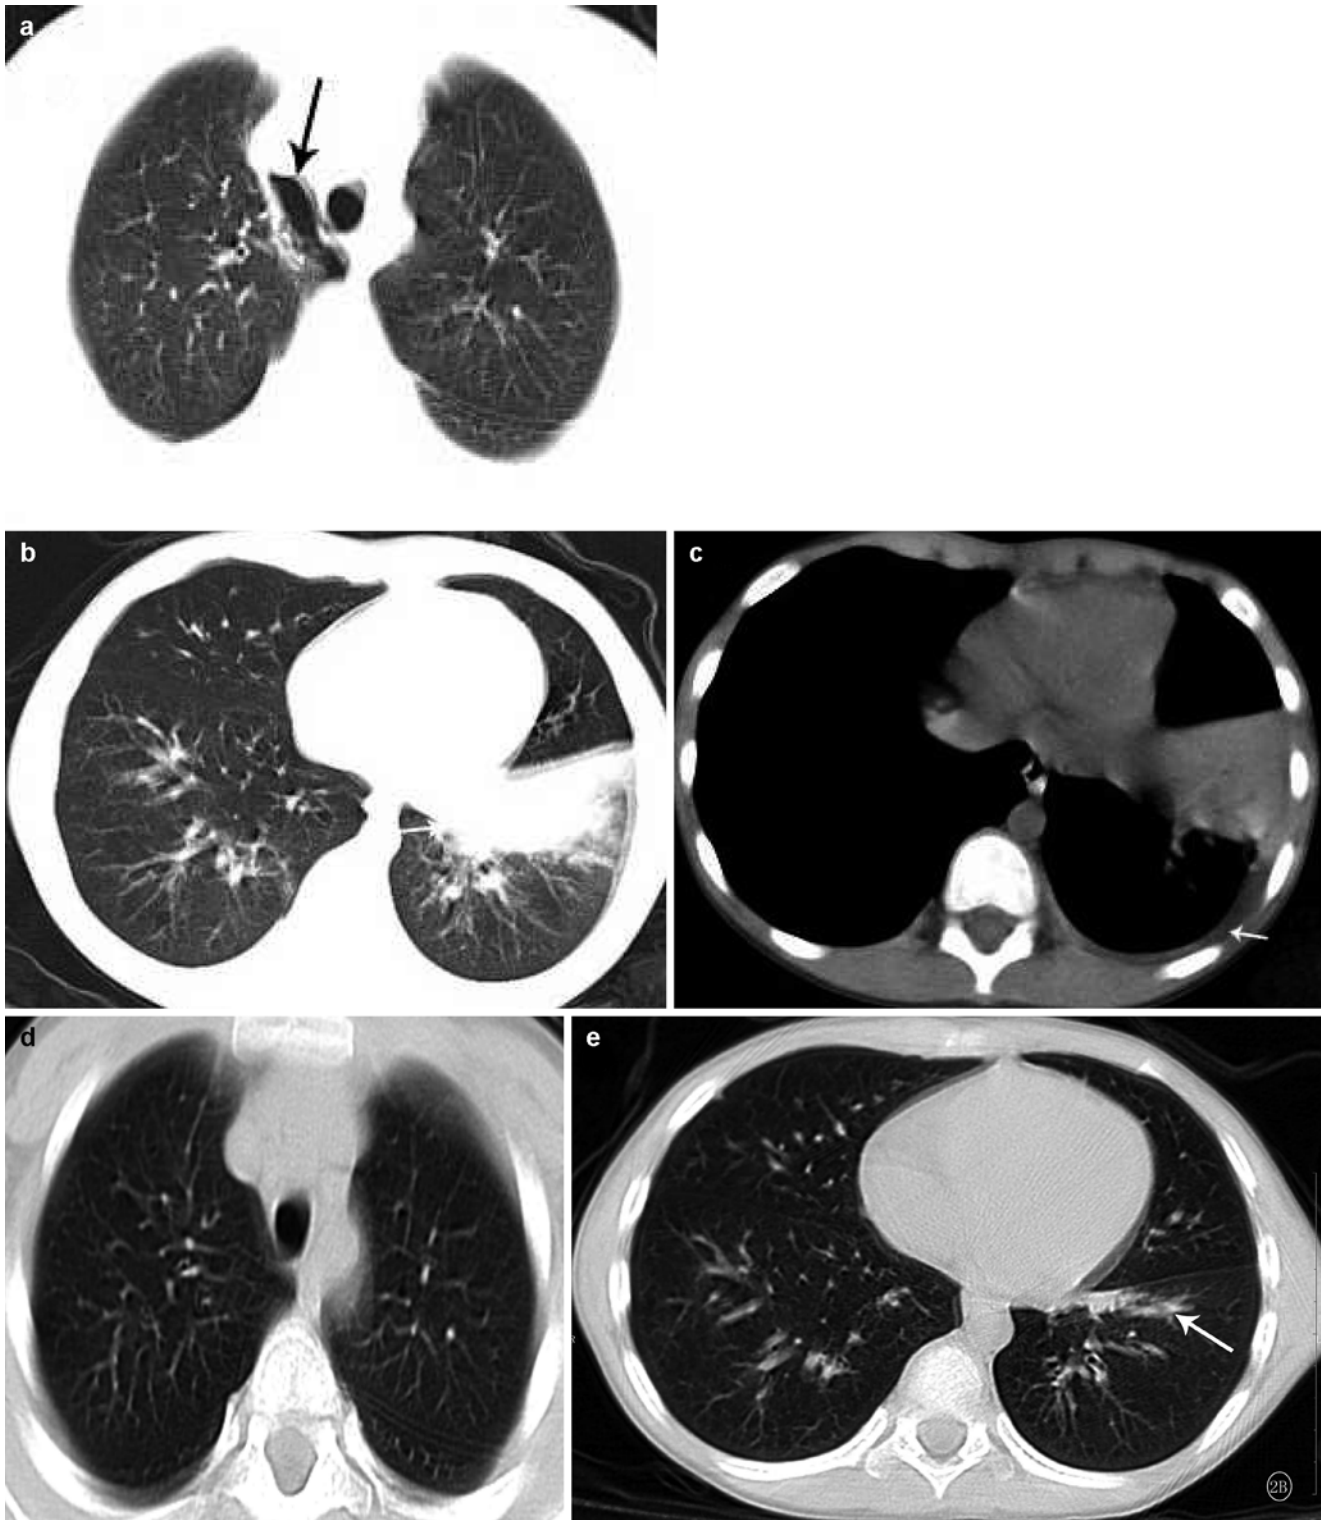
(a–e) A boy aged 7 years with influenza A (H1N1) complicated by pneumonia. (a) At d 7 since onset, chest CT showed a strip-like area (*black arrow*) next to upper right mediastinum with no lung markings, which was preliminarily diagnosed as right pneumomediastinum; (b–c) The same chest CT at d 7 displayed large dense consolidation opacities (*black arrow*) at the left lower lung lobe immediately
